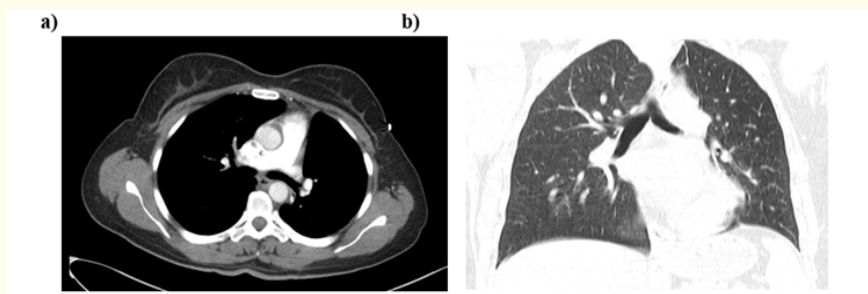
CT-scan 3 months after Semi Sleeve Resection of the Left Upper Lobe.
